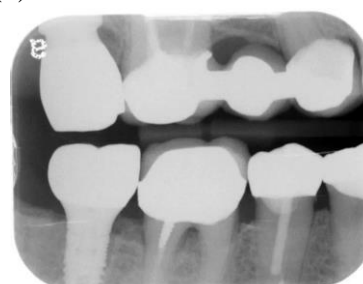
Radiograph of a restored Atlantis Ti-base implant restoration
